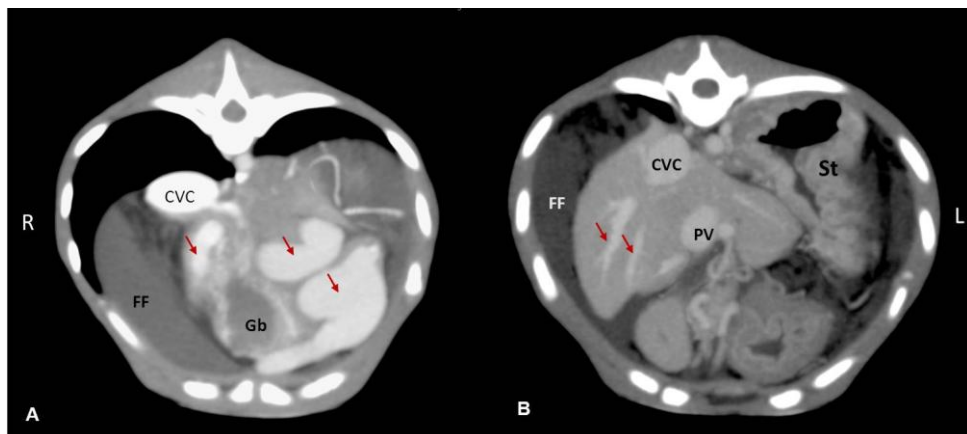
A: Transverse MIP image of the abdomen made during the arterial phase shows aneurysmal and dilated portal veins of the left lateral hepatic lobe (arrows). The vessels in the gallbladder wall (Gb) are distended (varicose veins). B: Transverse computed tomographic (CT) image made during the portal phase shows the normal portal veins of the right lateral hepatic lobe (arrows). The caudal vena cava (CVC) and portal vein (PV) are dilated. The vessels in the stomach (St) wall are distended (varicose veins). FF: free peritoneal fluid; R: right; L: left.
